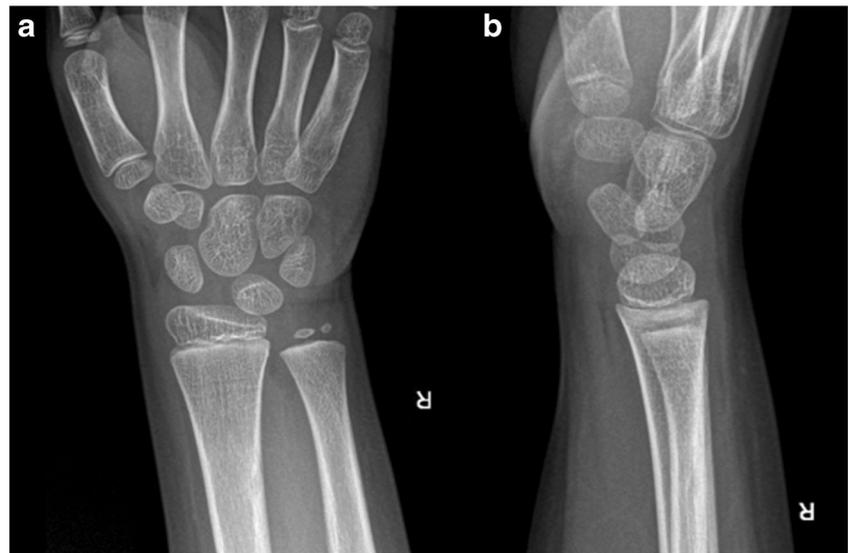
Radiographs 15 months following fracture demonstrating the near disappearance of the cyst-like lesion, barely visible on the ulnar side of the dorsal cortex of the radius
